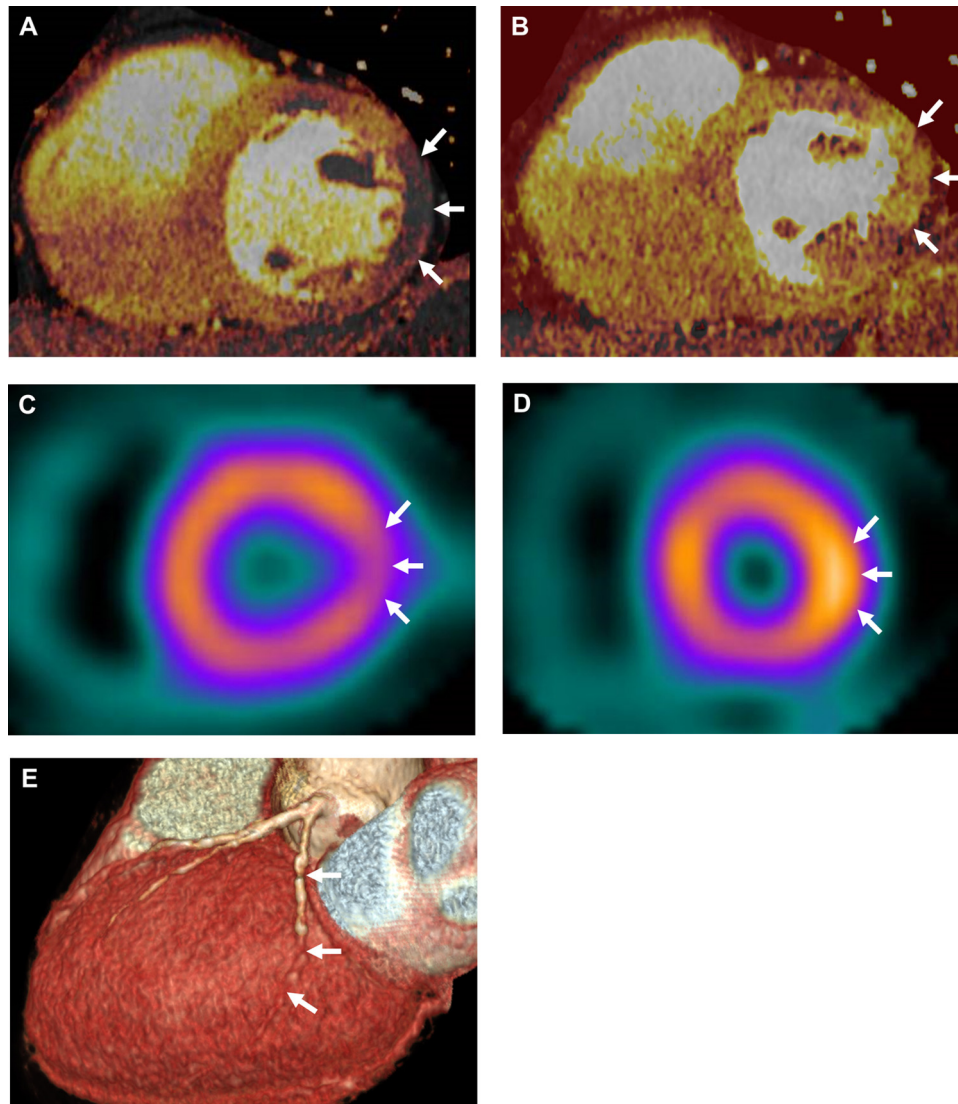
Stress dual-energy iodine distribution map in a 72-year-old man shows well-defined area of decreased iodine content (arrows) in the lateral wall of the left ventricular myocardium (A). Rest dual-energy iodine map in same patient reveals that the decrease of iodine content in the myocardium is reversible (B), which suggests the myocardial ischemia in the lateral wall. Rest (C) and stress (D) single-photon emission computed tomography images shows reversible perfusion decreases (arrows) at mid lateral wall, corresponded with the dual-energy CT iodine map. Volume rendering image shows diffuse luminal irregularities and intermediate-to-severe stenosis in the left circumflex artery (E).
